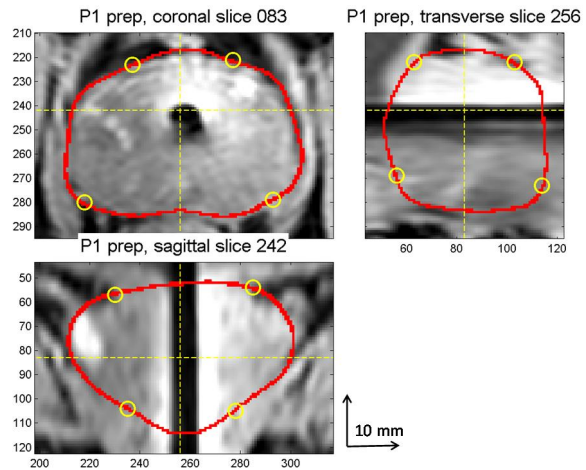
T1-weighted preparation image for P1. The manual segmentation and landmarks are defined for the planning image in Figure 1.
